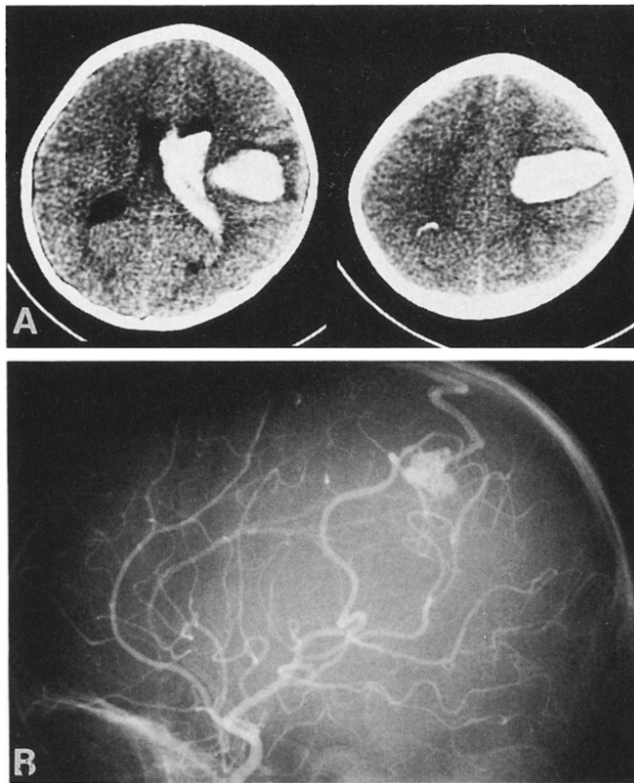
Case 3: Plain axial CT (A) showing a hyperdense area in the left fronto-parietal region, indicative of the presence of an intracerebral hematoma. Carotid angiogram with lateral view (B) disclosed an AVM. The arterial supply, nidus, and venous drainage are simultaneously visualized during the arterial phase on angiograms, suggesting an ordinary pattern of hemodynamics for AVM with a high flow shunt.
